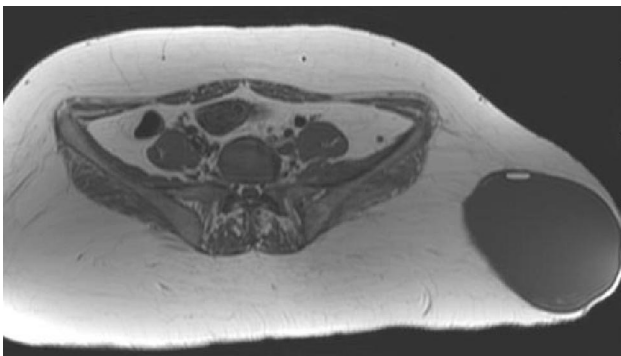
(b): MRI axial T1WI, fat globule in the CT scan is appearing hyperintense on T1WI.
